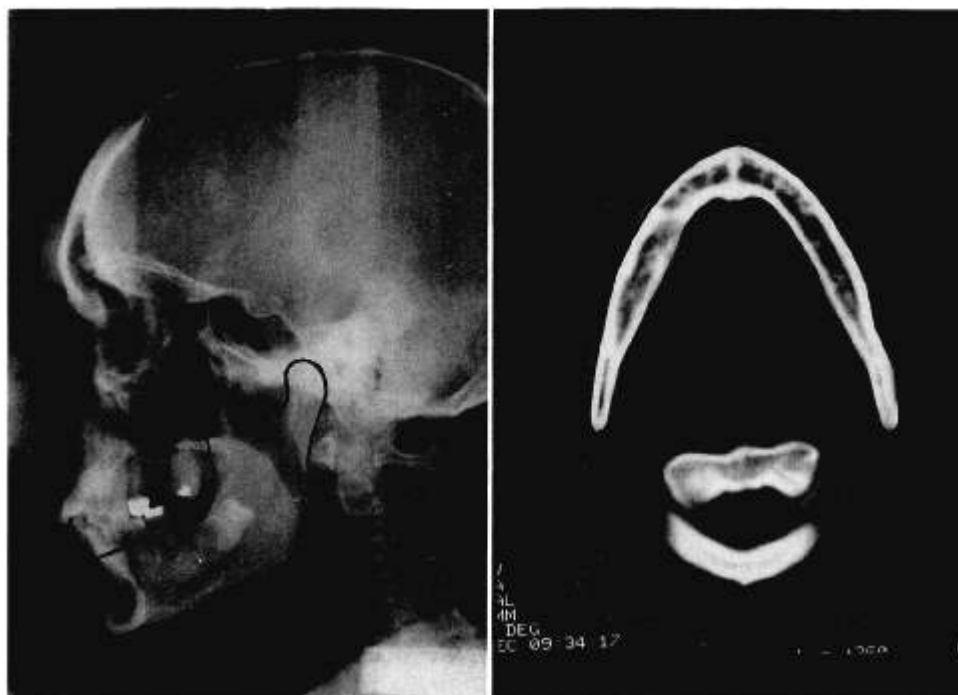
(Left) The mandible contour is shown marked on the lateral cephalogram. (Right) The contour in the transverse plane is marked on the CT scan image reproduced on a 1:1 scale. Templates of flexible clear acrylic are cut out from these tracings for intraoperative use.
